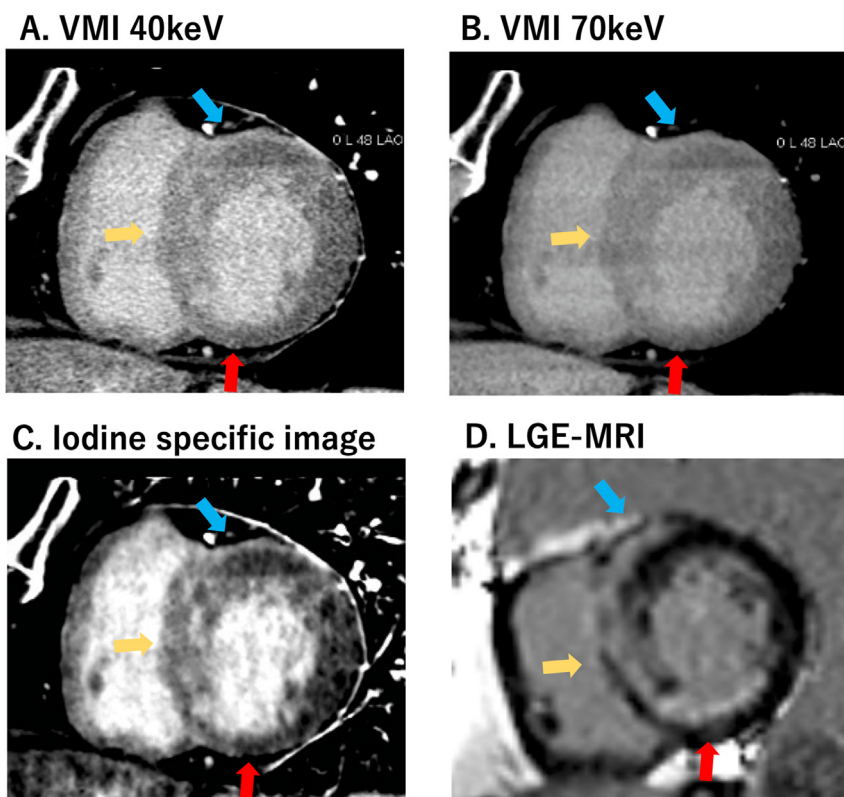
CT-LE imaging with dual-energy CT in a patient with occluded right coronary artery and cardiac sarcoidosis. Myocardial CT-LE image shows subendocardial infarction in the inferior wall (red arrow), striated nonischemic enhancement (yellow arrow) in the mid-wall of the interventricular septum, and non-ischemic enhancement (blue arrow) in the epicardium of the anterior wall. The contrast of the lesion is higher in the VMI of 40 keV(A) and the iodine-specific images (C) compared with that of the 70 keV image (B). These lesions are in good agreement with LGE-MRI (D). CT-LE, computed tomography late enhancement; CT, computed tomography; VMI, virtual mono-energetic image. (For interpretation of the references to colour in this figure legend, the reader is referred to the Web version of this article.)
